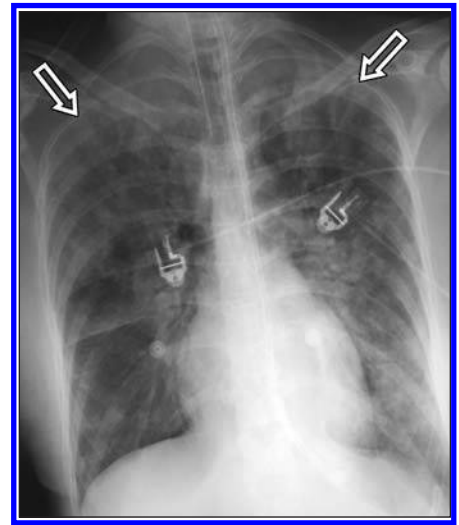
Neurogenic pulmonary edema in intracranial hemorrhage. Anteroposterior chest radiograph shows bilateral airspace consolidations (arrows), which predominate in upper lung zones. There is enlargement of central pulmonary artery, although heart size is normal.
